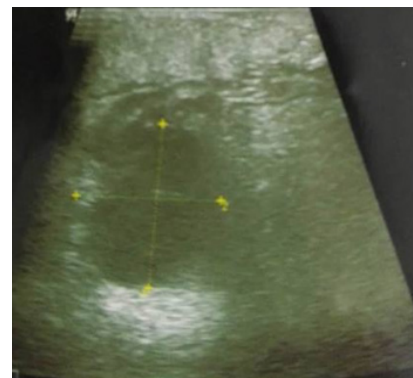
Right calf ultrasound: Popliteal cyst.
